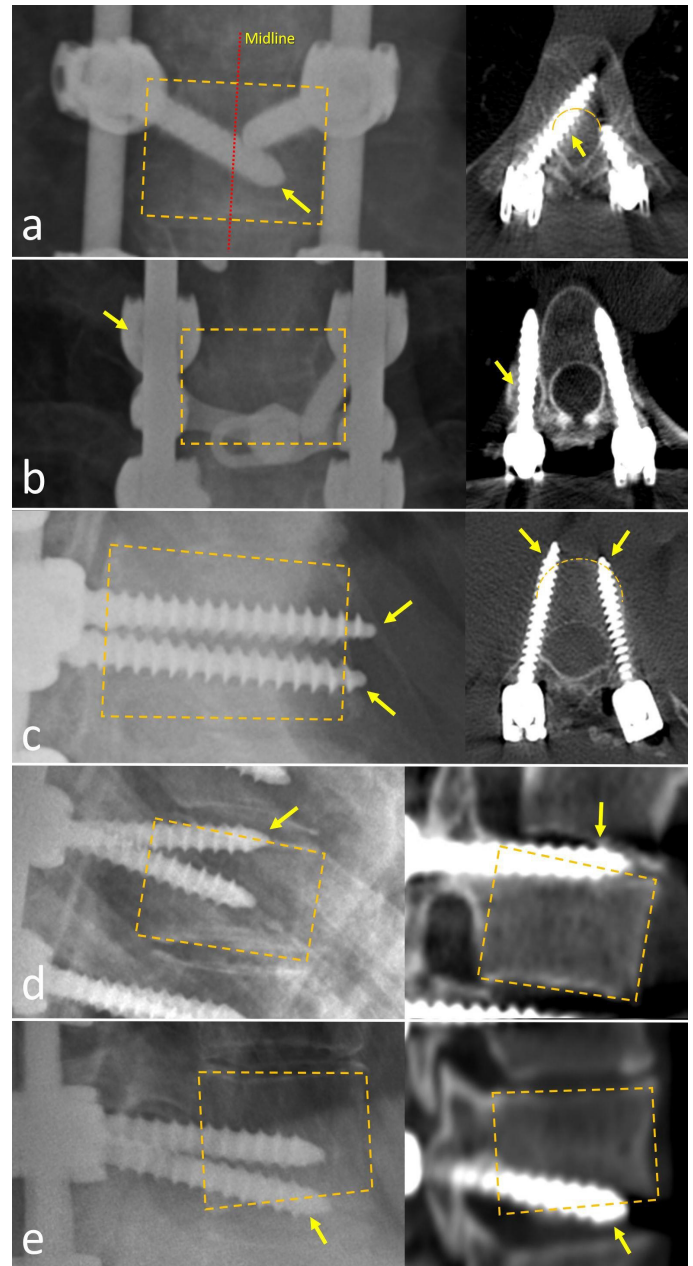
Five criteria used to assess the pedicle screw malposition on AP and lateral radiographs and representative CT images.
